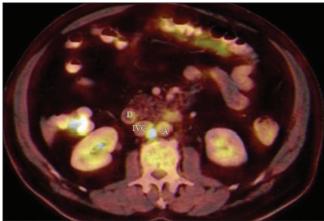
Positron emission tomography-computed tomography image showing intensely fluorodeoxyglucose-avid lymph node in between (posterior to) inferior vena cava (labeled IVC) and aorta (labeled as A), duodenum is labeled as D
